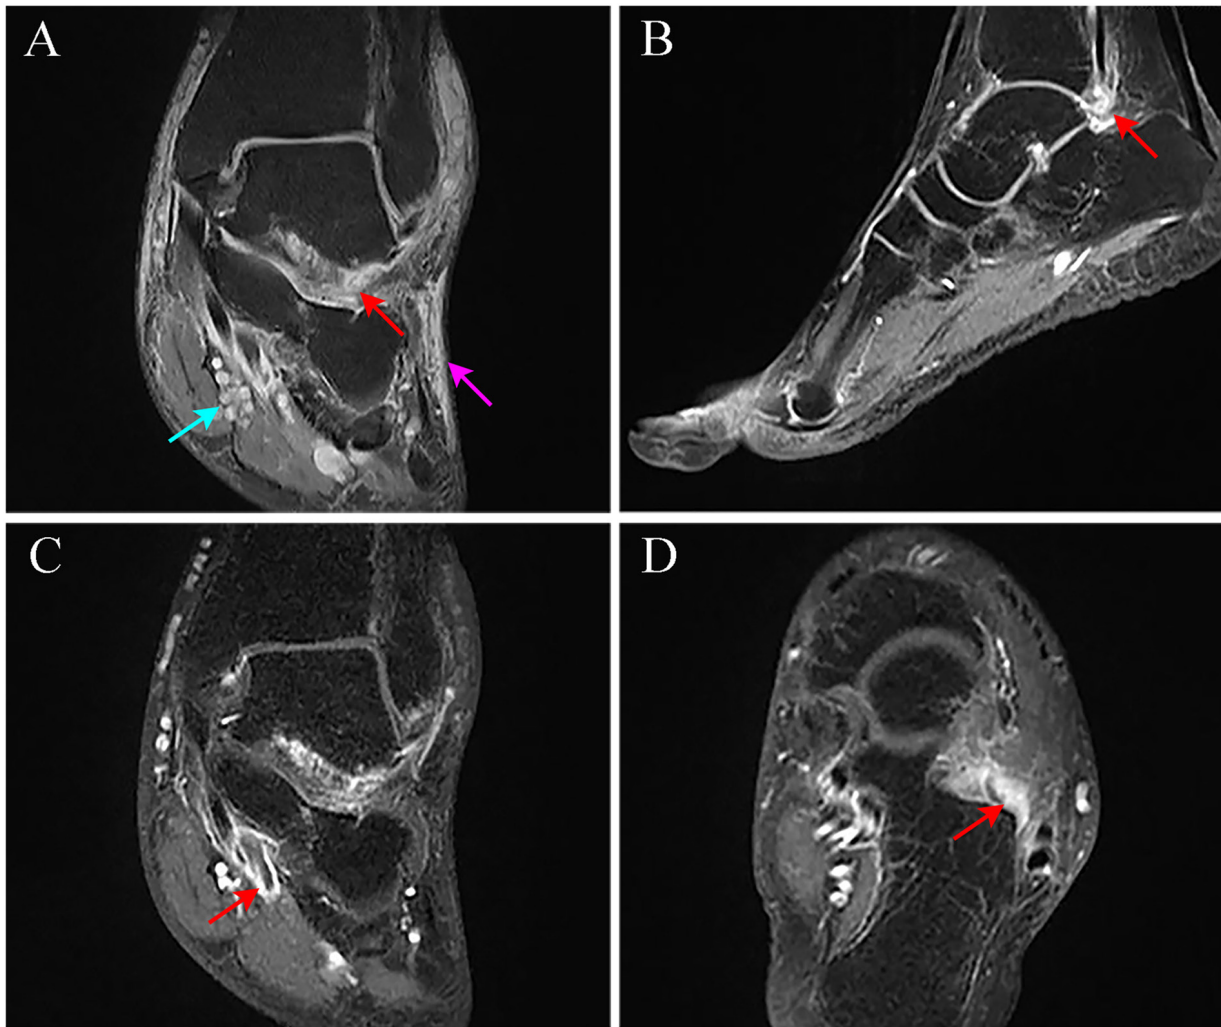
Magnetic resonance imaging of the left ankle in case 3. (A) Coronal T2-weighted fat-suppressed image shows tarsal sinus effusion (red arrow), subcutaneous soft tissue edema (purple arrow) and tibiotalar joint and bursal effusions (blue arrow), reflecting widespread intra-articular and periarticular inflammation. (B) Sagittal post-contrast T1-weighted fat-suppressed image demonstrates marked enhancement of the retrocalcaneal bursa (red arrow), indicating active inflammatory bursitis. (C) Coronal post-contrast T1-weighted fat-suppressed image reveals enhancement of the flexor tendon sheaths along the medial ankle (red arrow), consistent with active tenosynovitis. (D) Axial post-contrast T1-weighted fat-suppressed image shows diffuse synovial enhancement within the tarsal sinus (red arrow), an early indicator of inflammatory arthropathy in this region between the talus and calcaneus.
